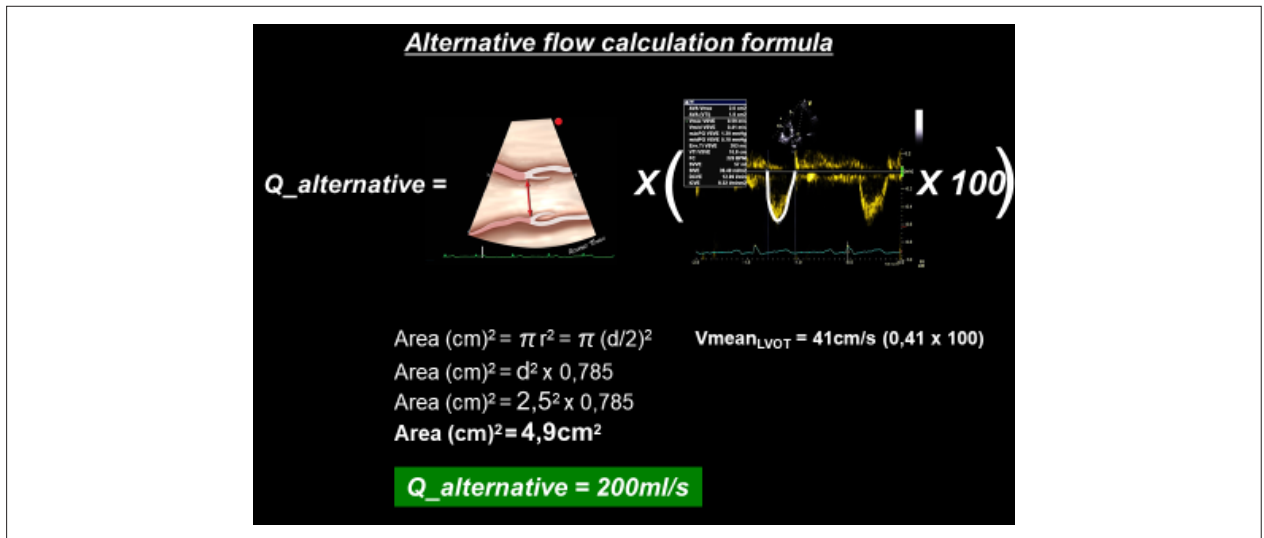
Alternative flow calculation formula where:  $Q_{\text{alternative}}$  is flow in mL/s,  $AST_{\text{LVOT}}$  is the sectional transverse area of the left ventricular outflow tract (LVOT) in cm<sup>2</sup>, and  $V_{\text{mean}_{\text{LVOT}}}$  is the mean blood flow velocity by pulsed wave Doppler at the LVOT level during left ventricular ejection, being expressed in m/s.
